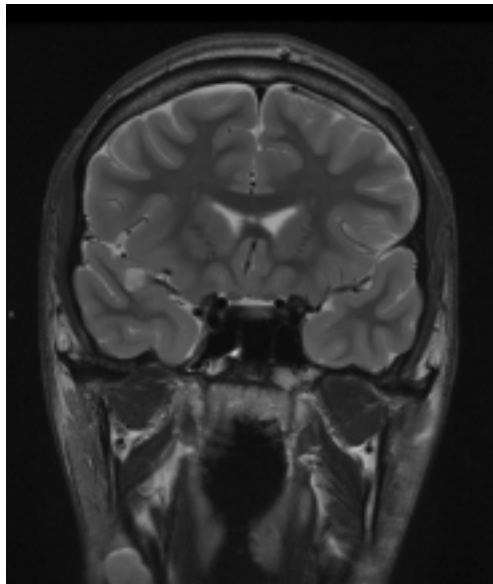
Right temporal lobe lesion on a T1 axial MRI.
